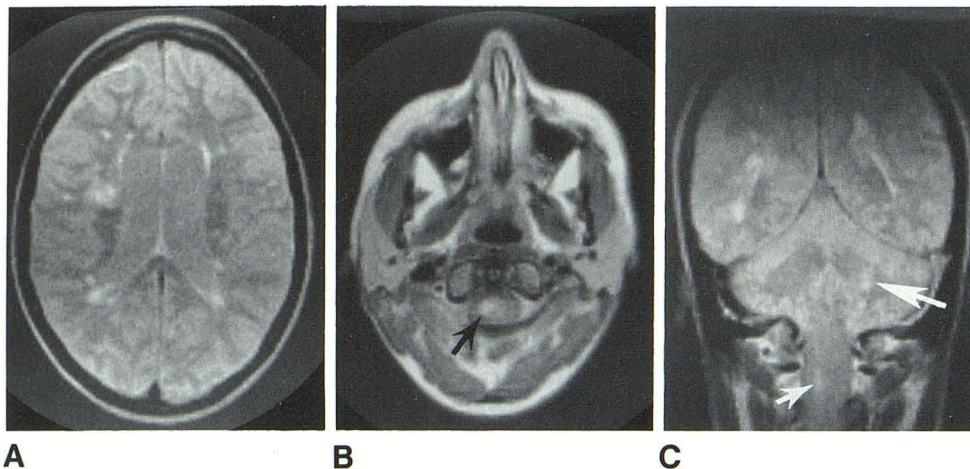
A, Characteristic changes of MS plaques. Abnormal areas of relative increased RF signal intensity in periventricular regions and within white matter of centrum semiovale. B, Transaxial MR image at level of C2. MS plaque in right side of spinal cord (arrow). Pathologically, spinal cord plaques often involve large cross-sectional areas and do not respect gray-white matter boundaries or fiber tracts. C, Coronal view confirms demyelinating plaque within upper cervical spinal cord at C2 (small arrow). Periventricular plaques around atrial trigones and prominent demyelinating plaque within left corpus medullare of cerebellum (large arrow).
